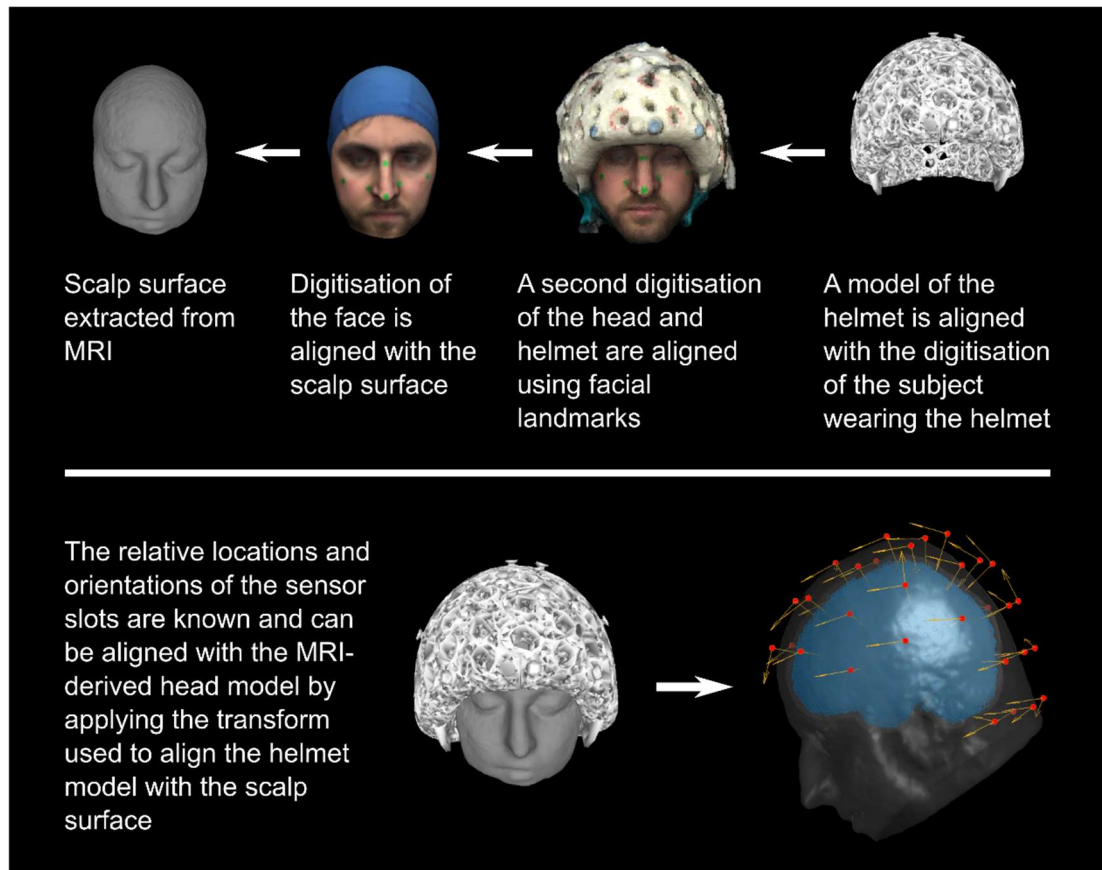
Coregistration procedure. Computer aided design (CAD) of the sensor helmet provides us with accurate knowledge of the relative positions and orientations of the sensors. To achieve full coregistration with the subject, we perform two 3D digitisations of the subject's head—one while wearing the sensor array and one while wearing a swimming cap to flatten any hair as much as possible. The head-only scan is aligned with the scalp surface extracted from the anatomical MRI and facial features are used to align the scan containing the helmet and participant's face. Aligning the CAD model with this latter digitisation yields coregistration between the subject anatomy and the sensor locations as shown in the image in the bottom right. Red dots depict sensor positions and yellow arrows indicate all sensitive axes of each sensor: one radial to the scalp surface for each sensor and an additional one or two tangential directions for dual and triaxial sensors respectively.
